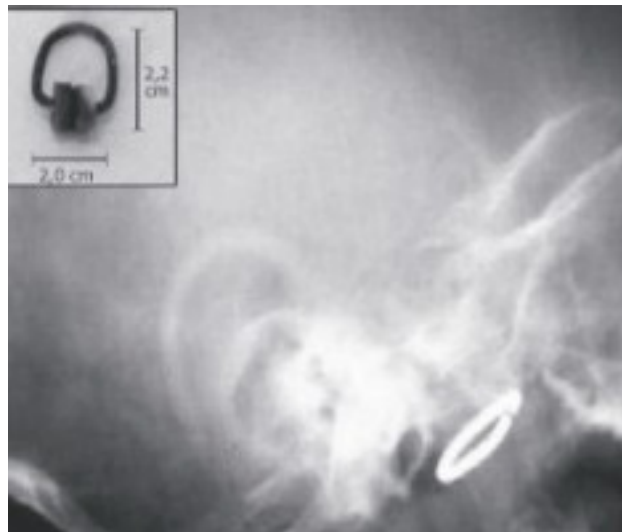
Oral jewellery as a radiographic artifact
